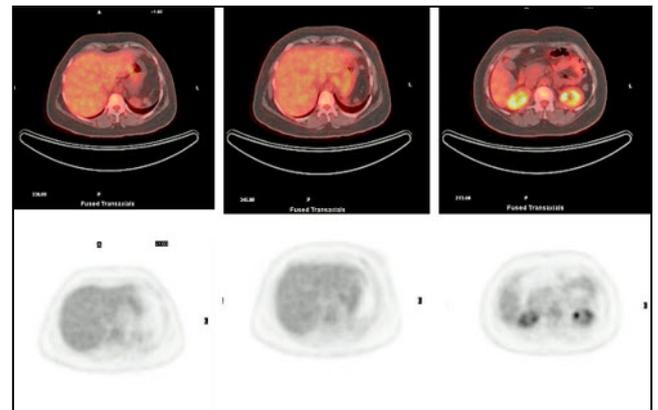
^{18}F -FDG PET/CT scan showing multiple hypodense non-FDG avid lesions within the abdominal cavity
